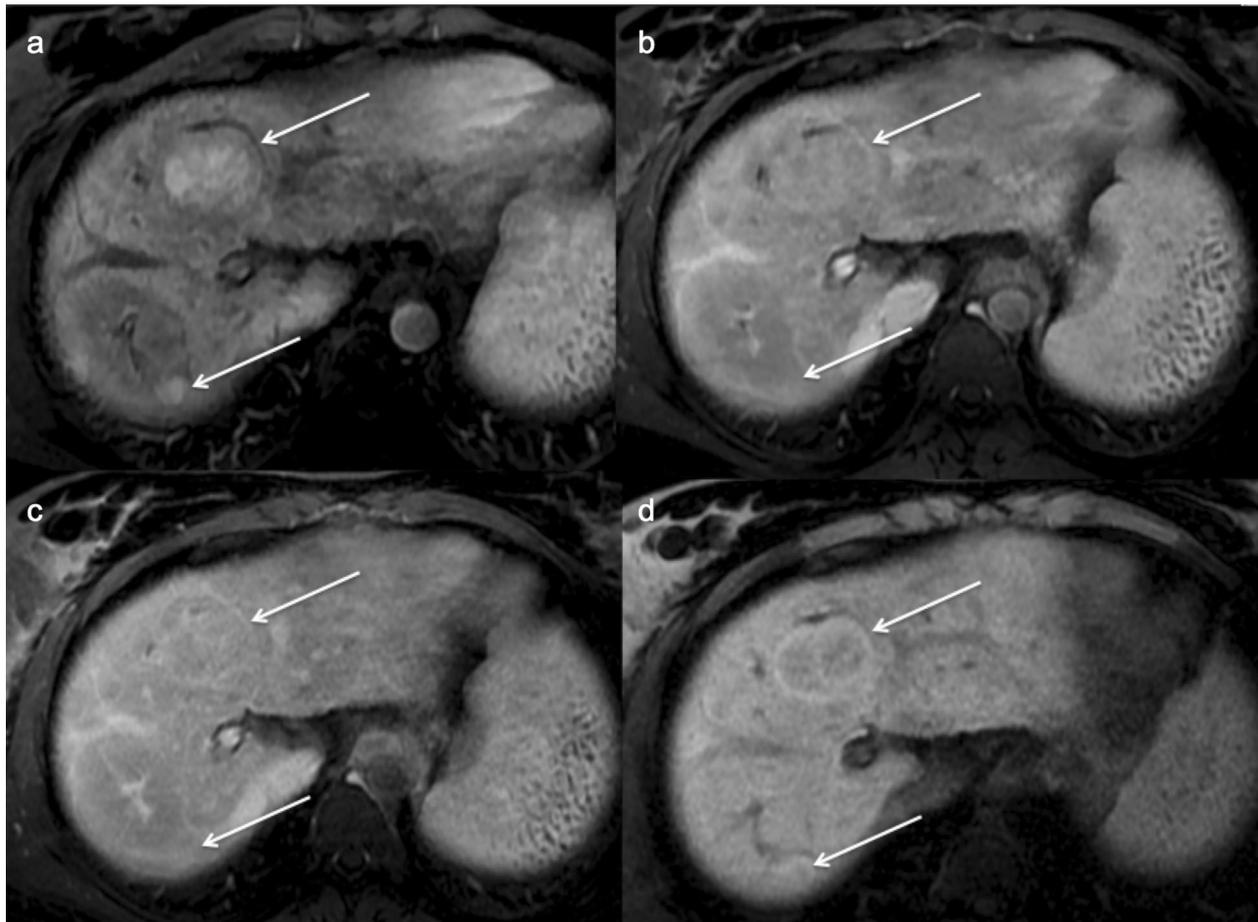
Congenital hepatic fibrosis. MRI in patient with congenital hepatic fibrosis showing hypervascular regenerative nodules (arrows) on arterial (a), portal (b), late (c) and hepatospecific (d) phases.
